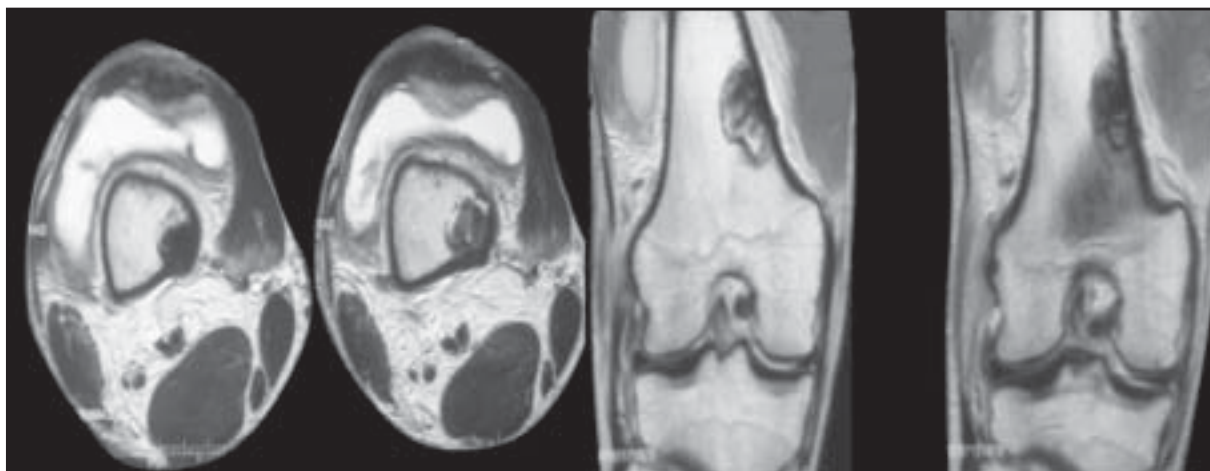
MRI images (axial and coronal sections) of the right knee showing the fibrous cortical defect. Knee joint shows synovial effusion with synovial hypertrophy.
